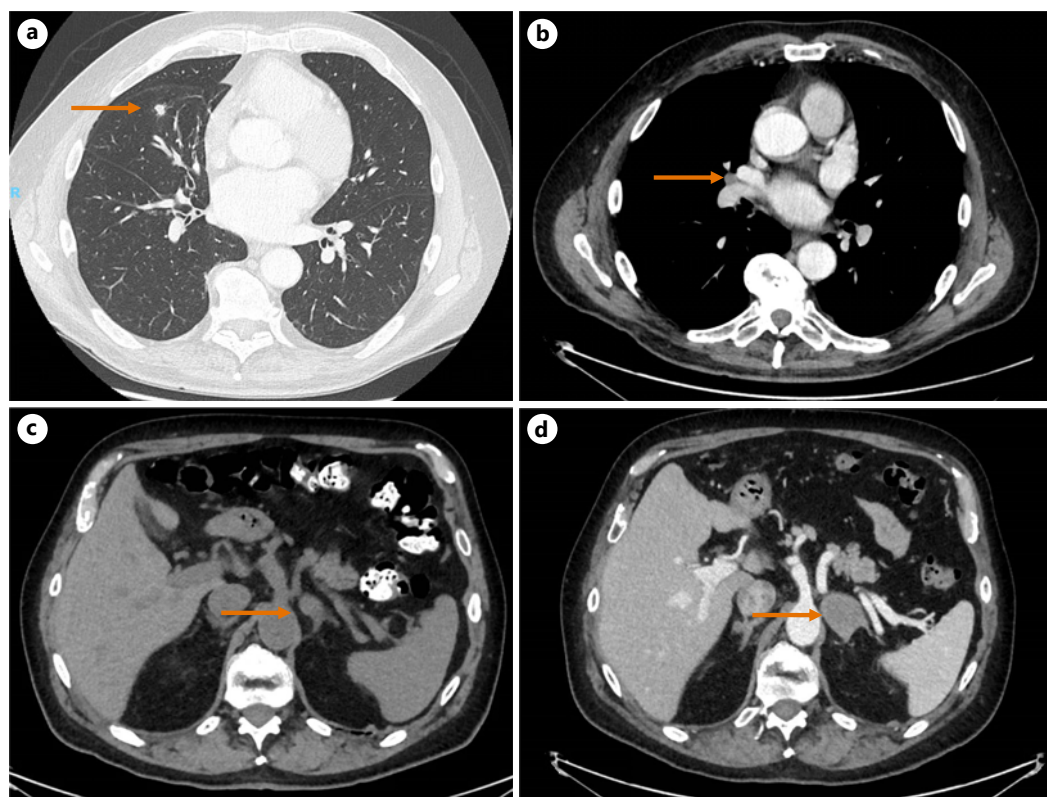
Contrast-enhanced computed tomography scan showing a spiculated right middle lobe nodule measuring 0.9 cm (a, axial view) and a right middle lobe intrapulmonary lymph node (b, axial view). Computed tomography scan demonstrating interval growth of left adrenal mass from 1.9 cm (c, axial view) to 3.7 cm (d, axial view).
